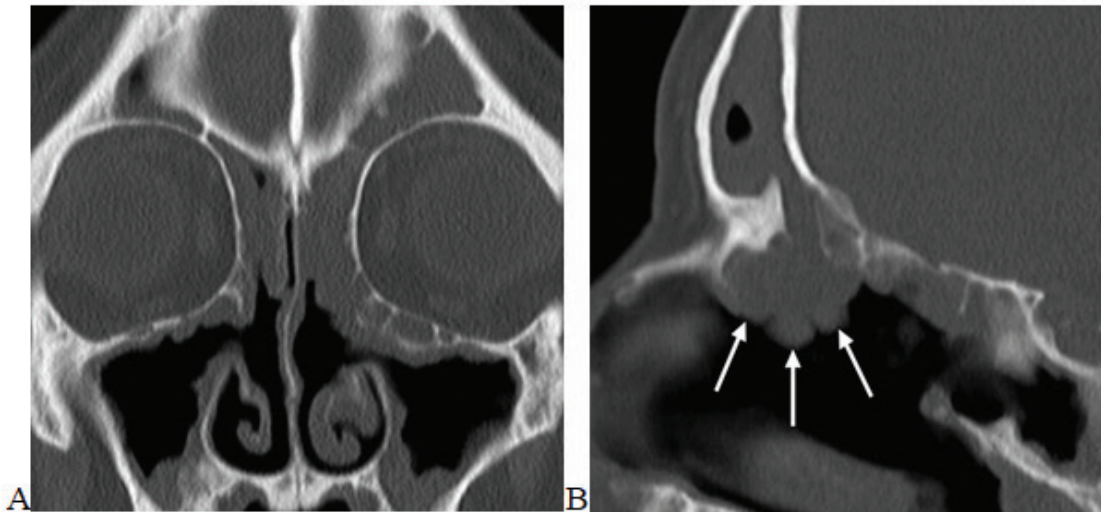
(A) coronal CT scan of patient with Samter's triad showing recurrence of polyps after FESS ⁽⁷⁾ (B) Sagittal CT scan of polyps recurrence ⁽⁷⁾
